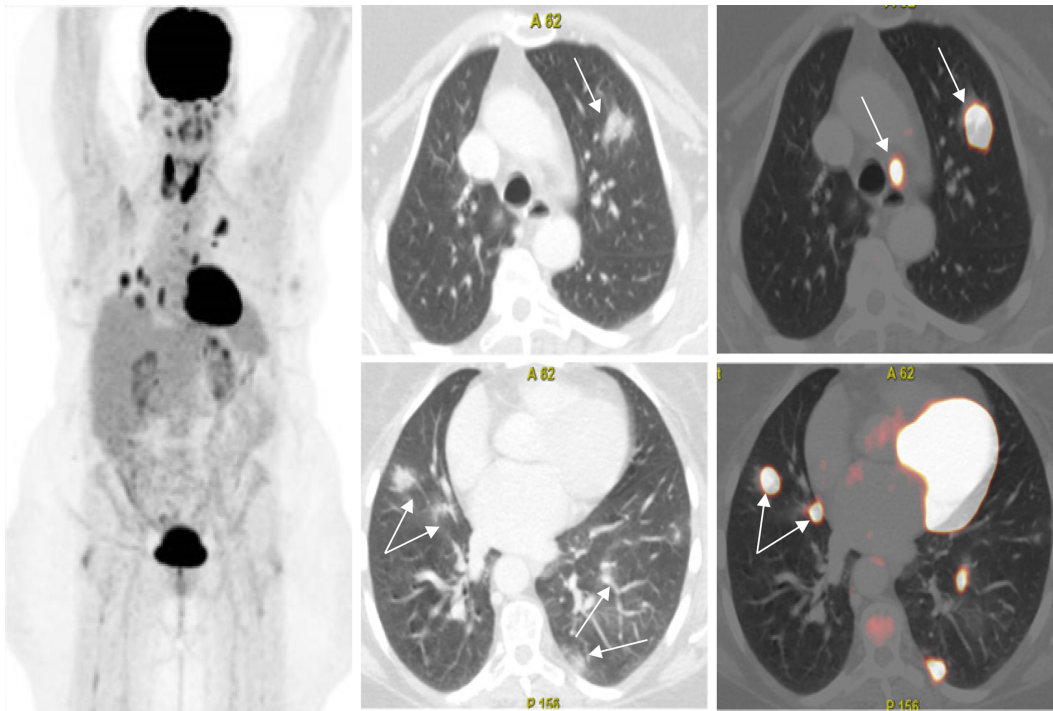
Axial fused thoracic ^{18}F Fluorodeoxyglucose-positron emission tomography-computed tomography showing multiple variable-sized metabolically active and mainly subpleural subsegmental consolidative lesions with an SUV_{max} of up to 10.9 as well as metabolically active lymph node seen in the aorto-pulmonary window in a patient with thyroid cancer and asymptomatic coronavirus 2019.
